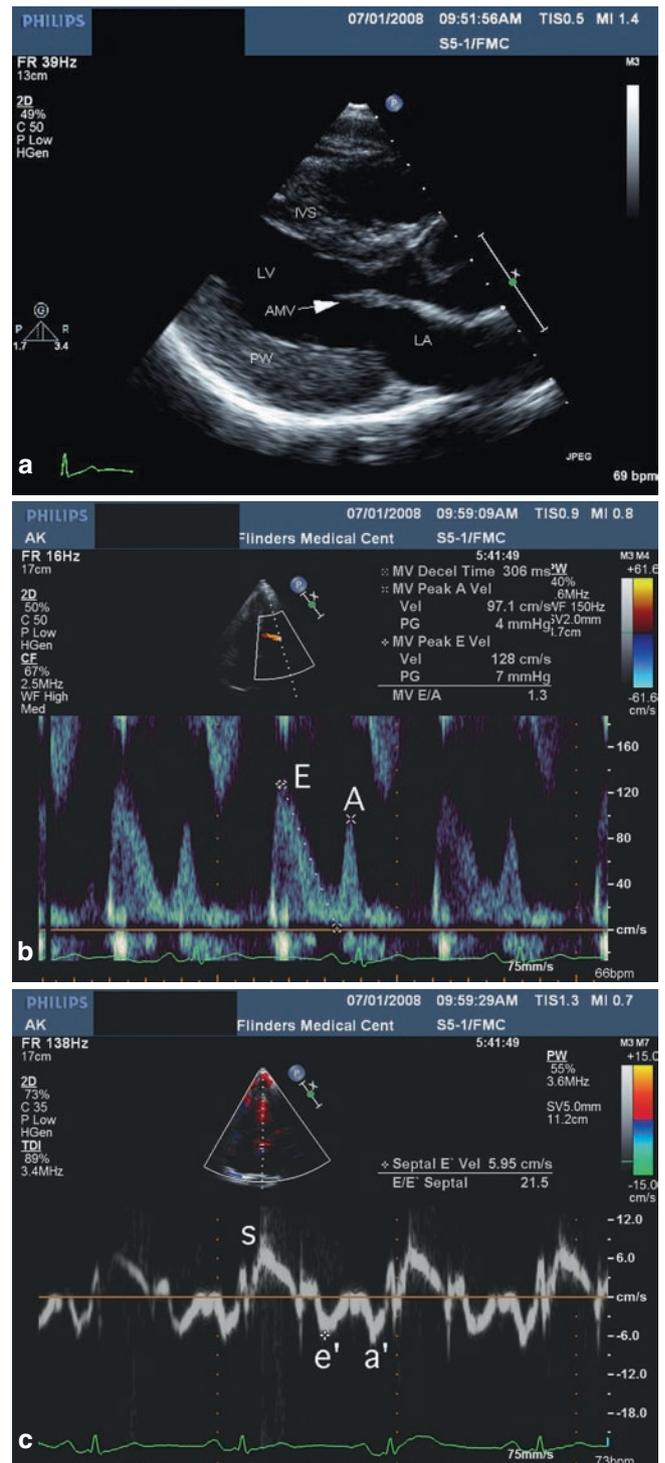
(a) 2D echocardiogram of a parasternal long-axis view in a patient with Fabry's disease demonstrating marked concentric LVH without cavity dilation. Thickening of the anterior mitral valve (AMV) is also seen. PW : posterior wall; IVS: interventricular septum; LA : left atrium; and LV : left ventricular cavity. (b) Doppler imaging: (a) Pulsed-wave Doppler of mitral inflow demonstrating ventricular (E-wave) and atrial filling (A-wave). (b) Tissue Doppler imaging of basal septum showing contractile (S) and relaxation velocities (E' and A'). The E' is markedly reduced with increased E/E' demonstrating an elevated LV filling pattern of diastolic dysfunction
